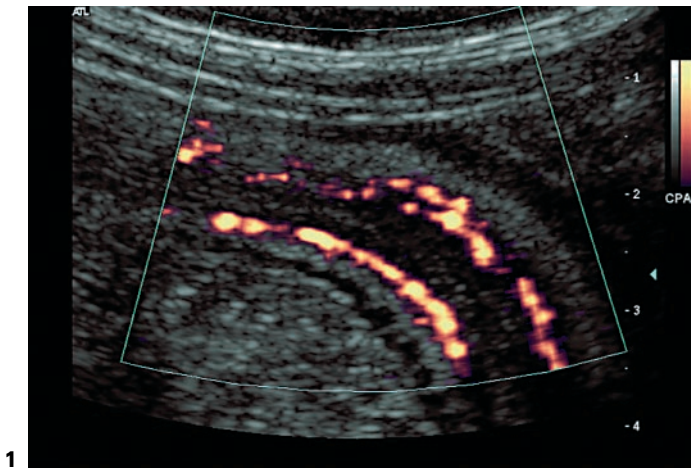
A thickened bowel loop in the sigmoid colon scanned with power Doppler sonography, the area of highest vascularization was selected by sector scanner.
